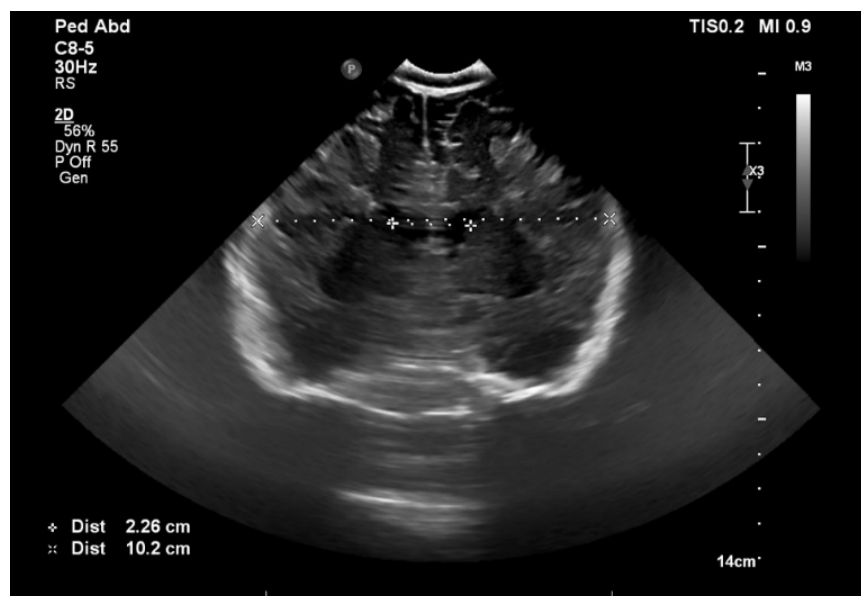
Transcranial ultrasound through the anterior fontanelle in the coronal plane revealed no abnormality. The ventricular index (measured) was normal for the patient's age and gender
